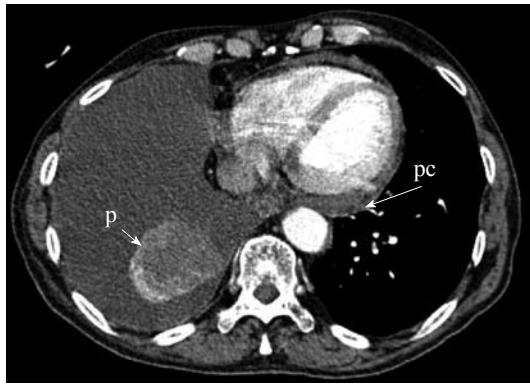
A patient with a necrotic mass in the right lower lobe (short arrow). As seen in this axial contrast enhanced computed tomography, there is pleural (p) and pericardial (pc) effusions which were confirmed to be malignant. This will be re-classified from T4 to M1a indicating worse estimated prognosis.
